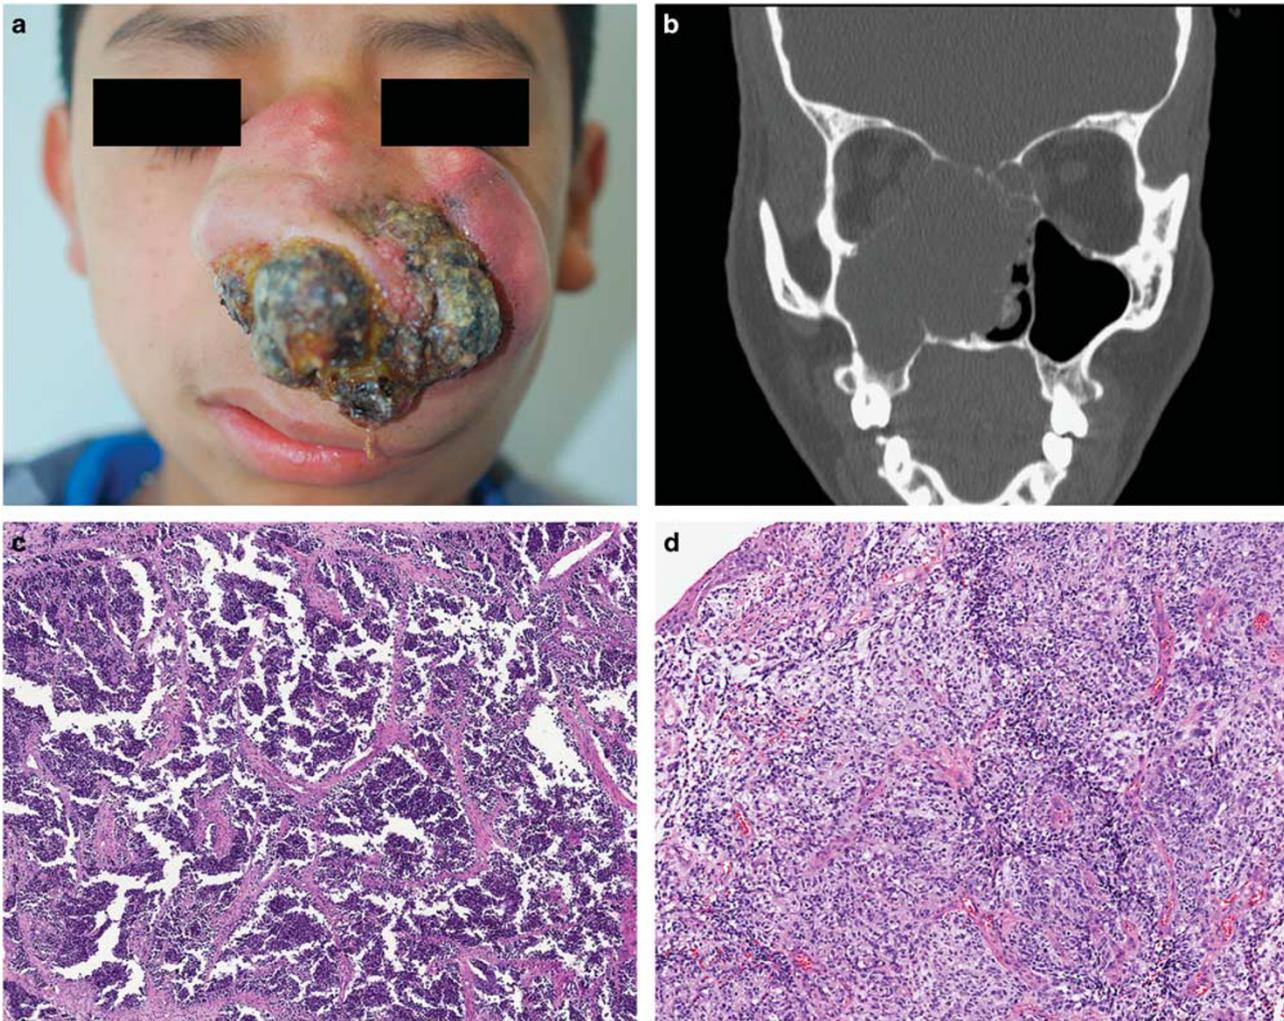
Rhabdomyosarcoma. (a) A large destructive mass of the nasal cavity, expanding into the soft tissues (photo courtesy Dr R Carlos). (b) A large destructive midline mass on computed tomography, expanding into the maxillary sinus. The low-power alveolar pattern with fibrous septa (c) helps in the differential diagnosis of this tumor. A slightly more epithelioid pattern is seen in this rhabdomyosarcoma (d).
